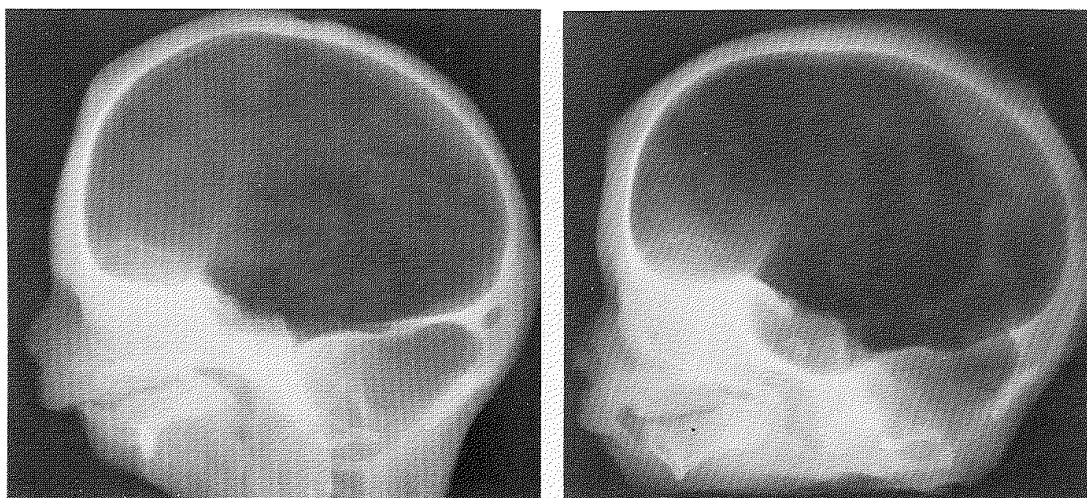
(left) MFD fetus, half skull lateral radiograph demonstrating the shape and position of the mandible and cranial base. Figure 3B. (right) Normal fetus, half skull lateral radiograph.
